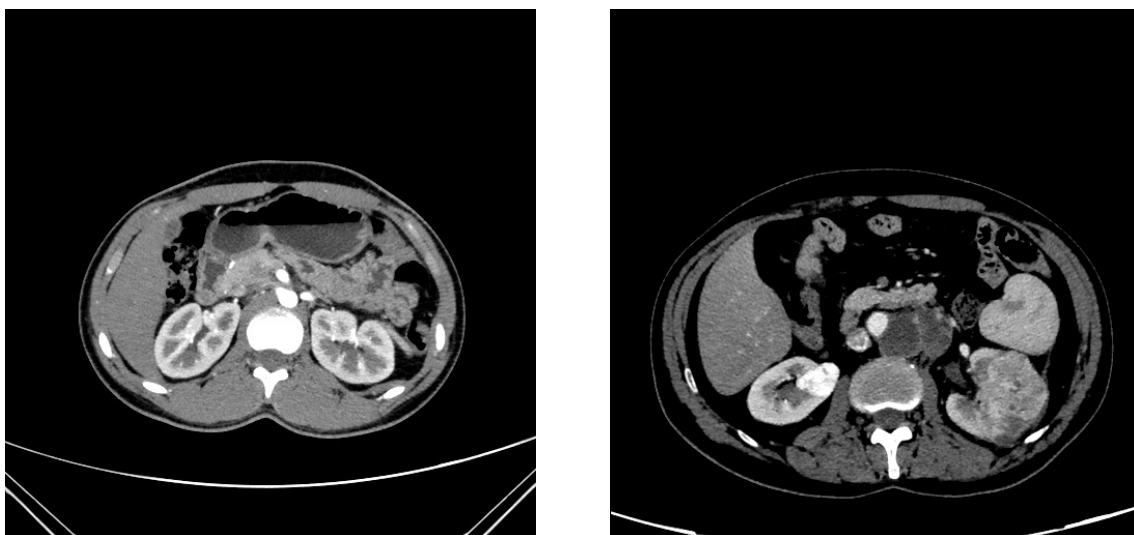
CT slices of patients.
